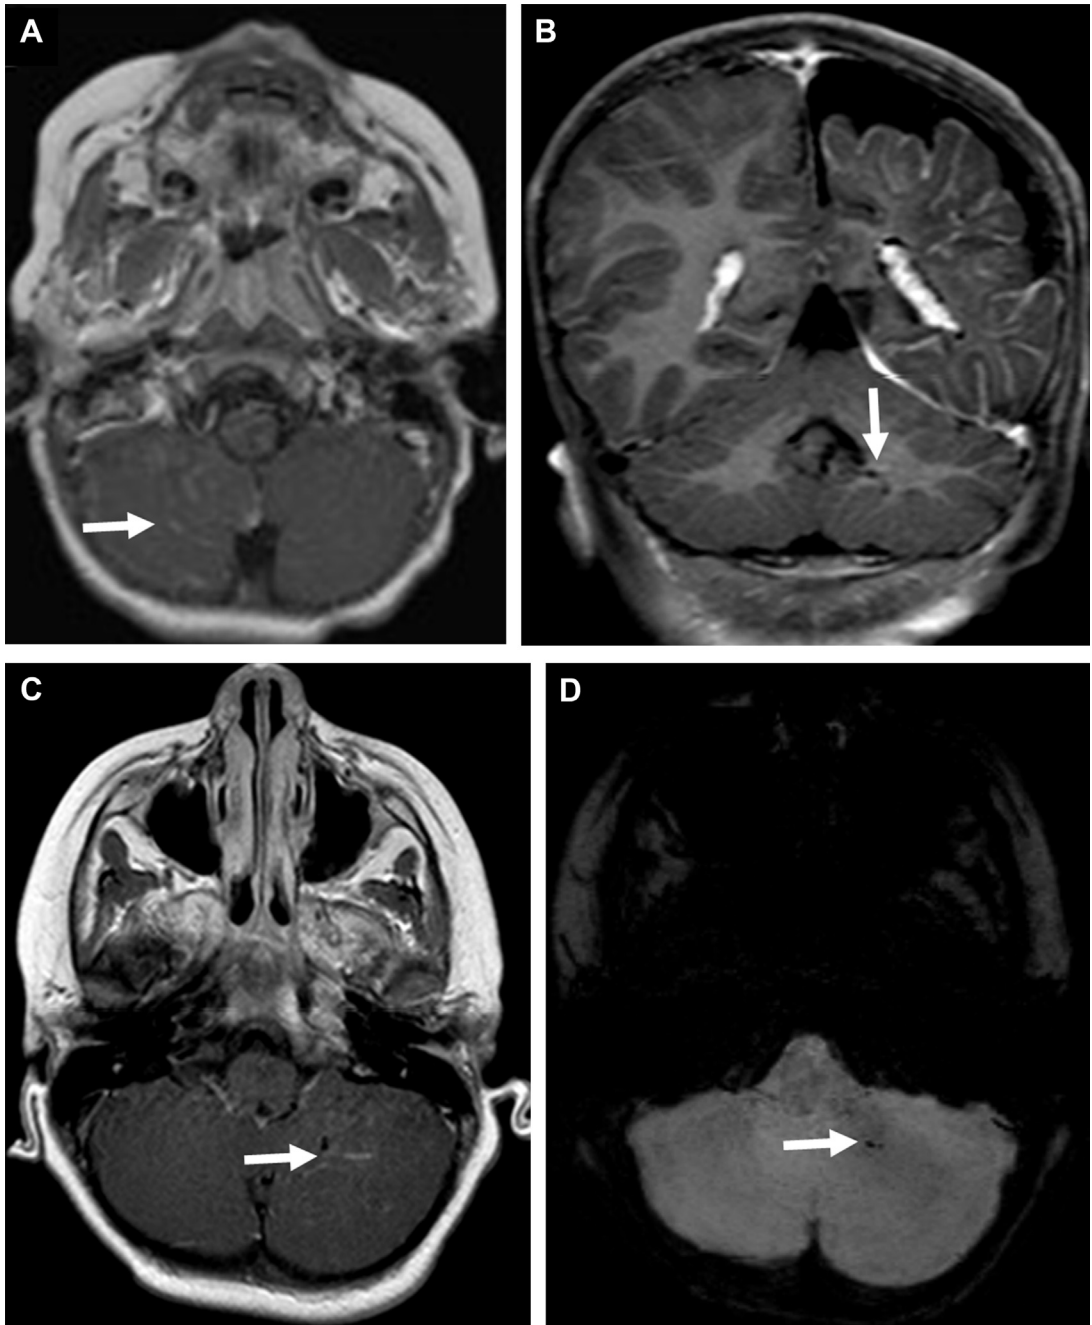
SWS. (A) Axial T1 postcontrast image showing an enhancing leptomenigeal angioma within the cerebellar fissures on the right (*arrow*). (B) Coronal (*arrow*) and (C) axial T1 postcontrast image showing developmental venous anomaly (DVA) in the left cerebellar hemisphere (*arrow*) and atrophy in the left cerebrum. (D) Axial SWI image showing hypointense signal in the left cerebellar hemisphere DVA (*arrow*). (From [A] Arulrajah S, Ertan G, M Comi A, et al. MR imaging with diffusion-weighted imaging in children and young adults with simultaneous supra- and infratentorial manifestations of Sturge-Weber syndrome. *J Neuroradiol* 2010;37:51–9; with permission.)
